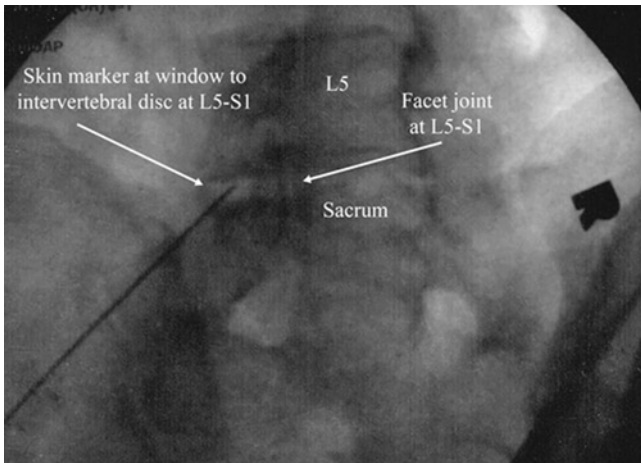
Oblique radiographic view of entrance site
